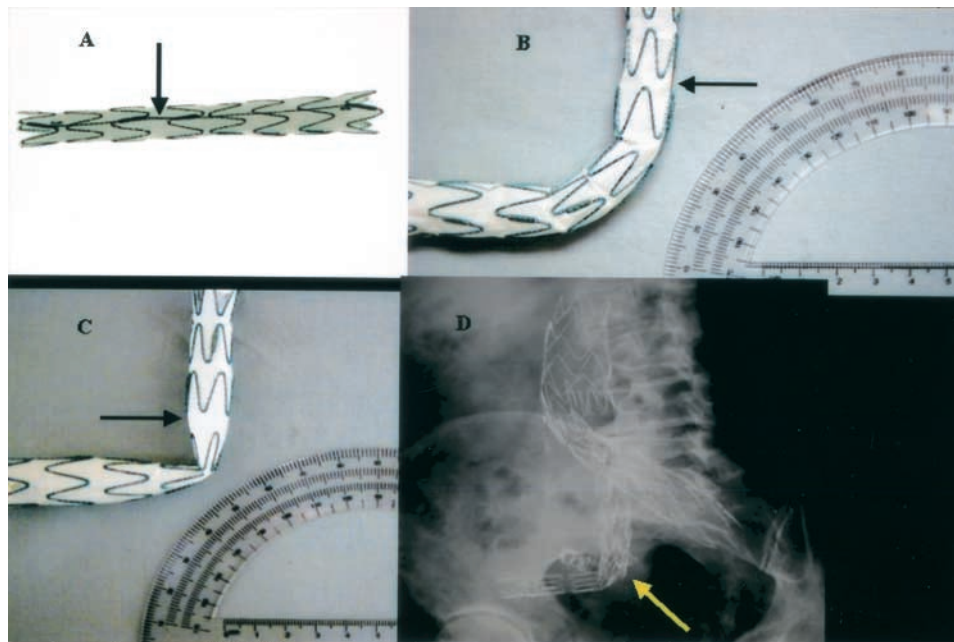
Endograft limb from bifurcated aortic modular graft. A, Limb with *arrow* indicates single longitudinal support bar. B, Angled endograft with support bar is shown with *arrow* on greater curve. C, Angled endograft with support bar on lesser curvature (*arrow*) resulted in endograft kinking. D, Abdominal radiograph is shown with kink (*arrow*) in endograft that extended to external iliac artery. Coils are present from preoperative embolization of internal iliac.
